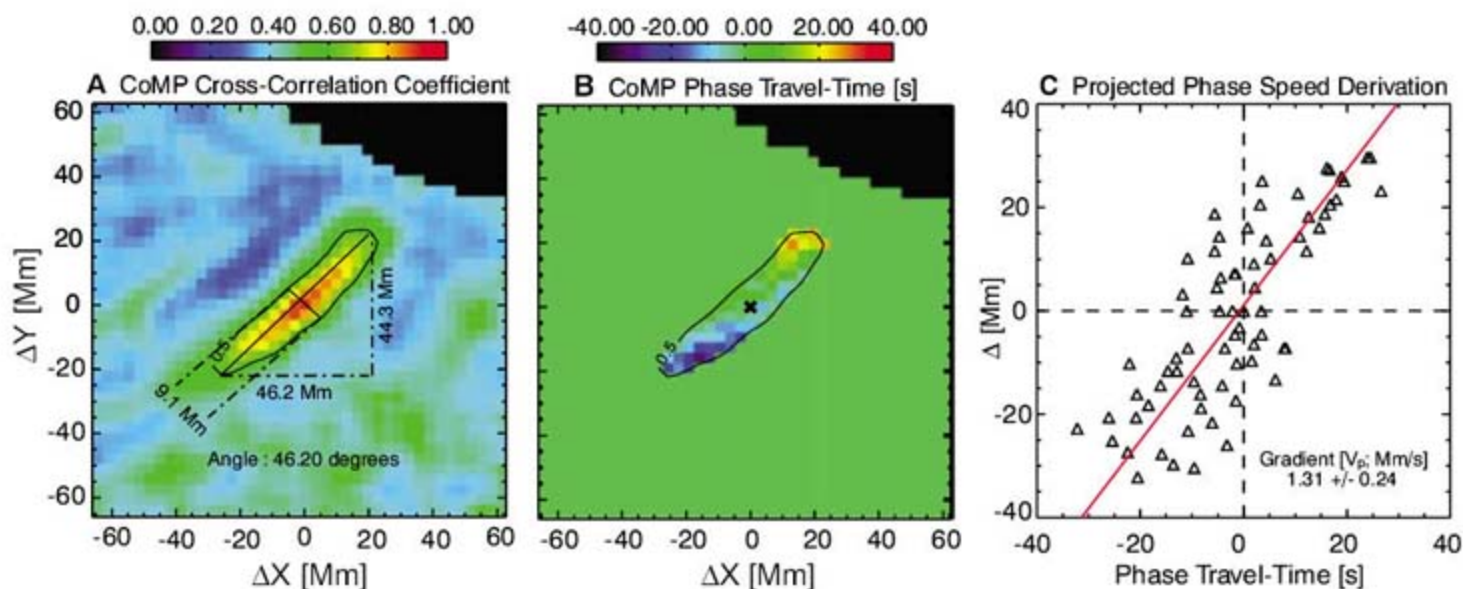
Travel-time analysis of CoMP Doppler velocity measurements for the reference pixel (marked by the x) over the boxed region shown in Fig. 1. (A) The map of cross-correlation coefficients with a contour of 0.5 , which is used to determine the properties of the waves. (B) The map of computed phase travel times in the same region (the surrounding pixels are zeroed for clarity). (C) The relationship of phase travel time against the distance to the reference pixel; the phase speed of the wave in this region is estimated from a least-squares linear fit.
